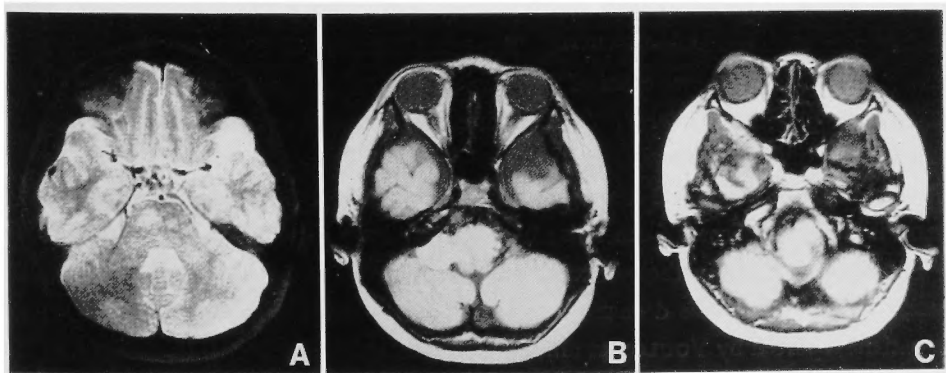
MR images on second admission, showing two exophytic extensions of the lesion (B & C, 1.5 Tesla, TR2000/TE20). Upper part of the intraaxial tumor is seen in A (TR2000/TE80).
